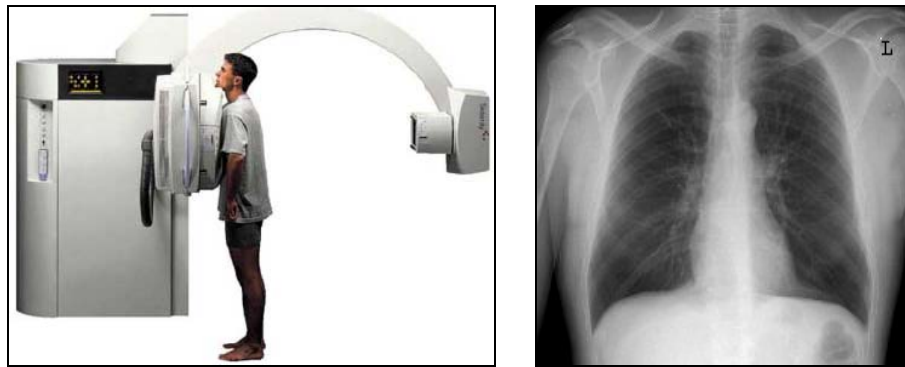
X-ray machine and Postero-anterior view of one chest radiography image. (source: <http://www.radiologyinfo.org/>)
